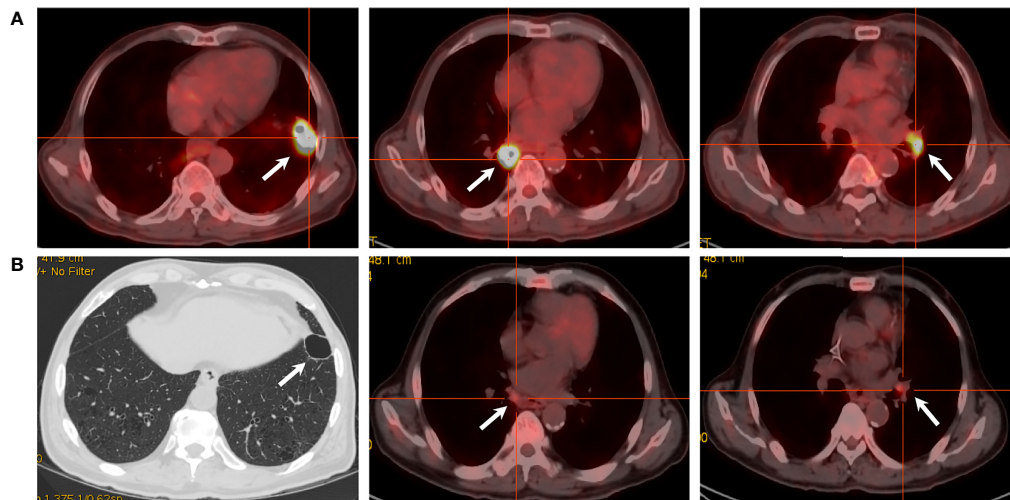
PET/CT scans of the target lesions. (A) Before toripalimab and chemotherapy administration in February 2020, PET/CT showed three lesions with intense hypermetabolic activity. (B) After 4 cycles of the combination treatment in June 2020, the solid portion of the left lower lobe lung mass disappeared with a cavity left. Also note the dramatic decrease in the size and metabolism of the other two masses.
